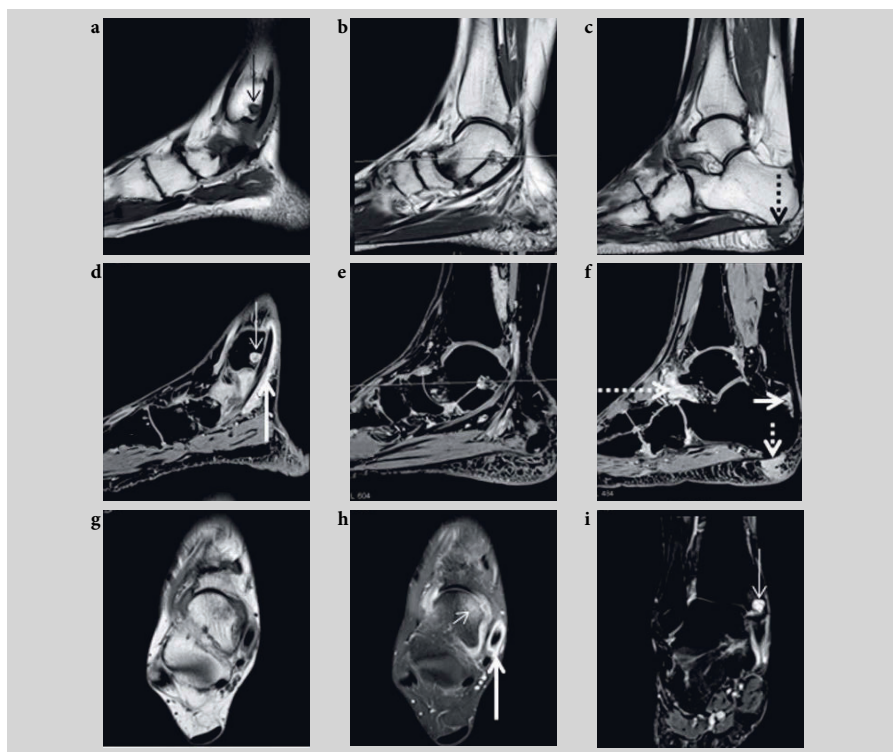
Magnetic resonance imaging (MRI) of the ankle and hindfoot of a patient with rheumatoid arthritis. (a–f): Sagittal T1-weighted MRI before (a–c; with fat suppression) and after (d–f; with fat suppression) intravenous contrast injection, through three different sections of the ankle and hindfoot. (g) axial T1-weighted; (h) axial short tau inversion recovery (STIR); (i) coronal STIR MRI. The images show erosion in the medial malleolus (long thin arrow), tenosynovitis at the tibialis posterior tendon (long thick arrows), bursitis in the retrocalcaneal bursa (short thick arrow), synovitis in the ankle joint (long dashed arrow), bone marrow edema in the talus (short thin arrow), and a rheumatoid nodule in the heel fat pad (short dashed arrow).
